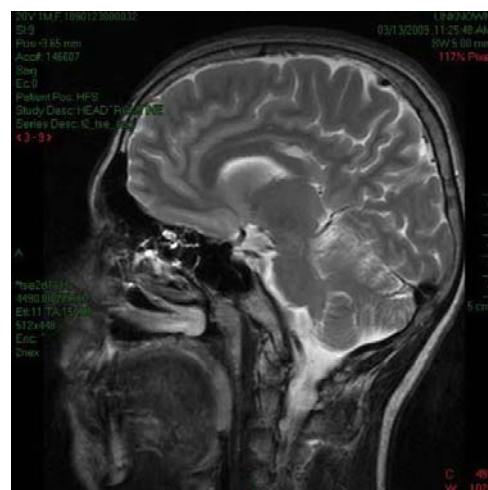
Interhemispheric lipoma and hypoplasia of corpus callosum on MRI sagittal section (T2)
